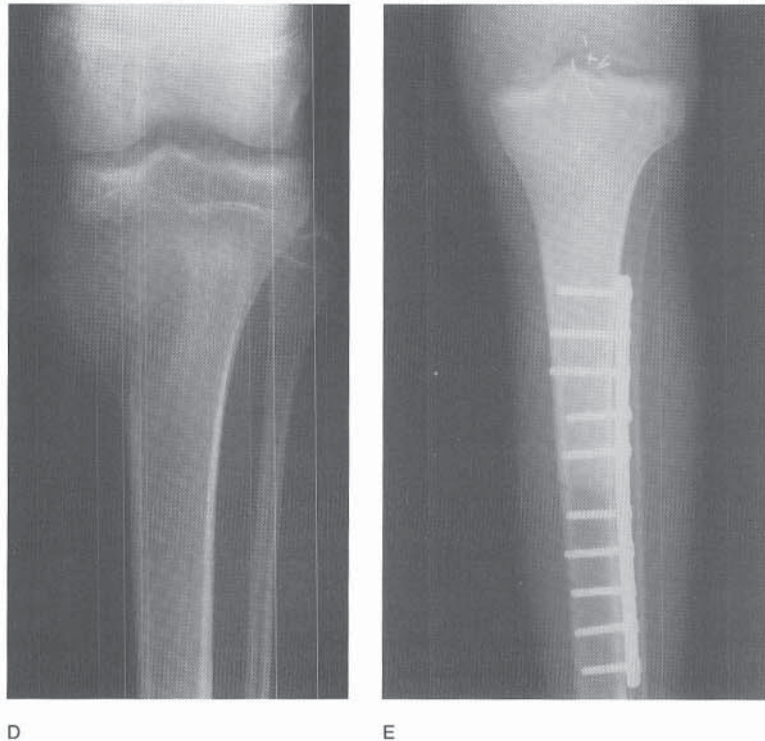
Continued.* D, AP radiograph obtained following preoperative chemotherapy. There is mineralization of the tumor, and a more complete periosteal shell of bone around the periphery of the lesion. This is considered to be a sign of response to chemotherapy. After preoperative chemotherapy, the patient underwent an intra-articular wide resection of the osteosarcoma and reconstruction with an osteoarticular allograft. E, AP radiograph showing the reconstruction with early healing of the osteosynthesis site 9 months after reconstruction.
